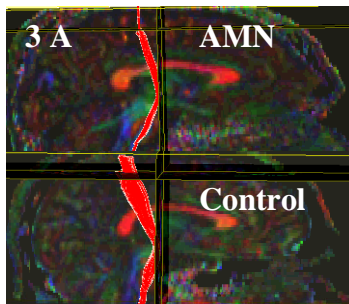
Grossly visible Atrophic Right. CST in 32 year old AMN patient compared to age match control male. Patient had severe spastic paraparesis. Conventional MRI was normal.
